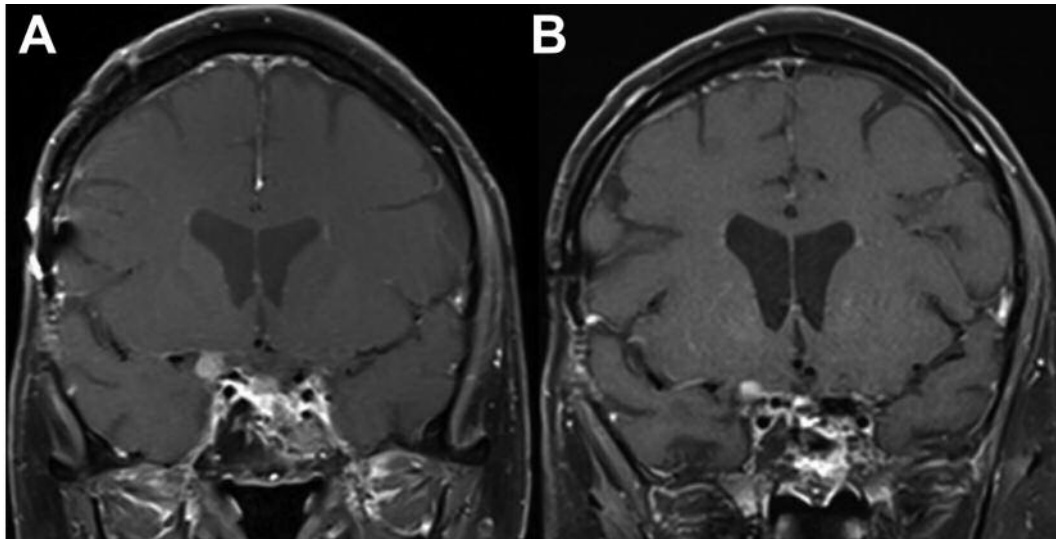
MRI of the brain showing the tumor in the right parasellar region of the pituitary gland (A) prior to targeted therapy initiation, as well as (B) four weeks after therapy initiation with recognizable tumor regression.
